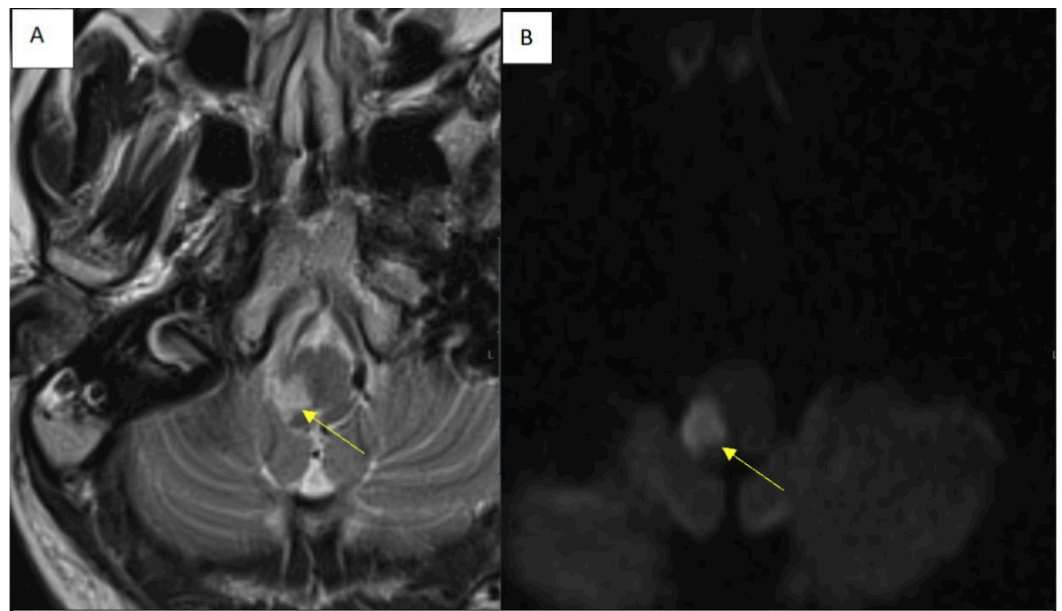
Magnetic resonance imaging (MRI) brain imaging axial T2 weighted imaging (T2WI) and diffusion weighted imaging (DWI) sequence at presentation. (A) Acute right lateral medullary infarct (yellow arrow) in the axial T2WI. (B) Acute right lateral medullary infarct (yellow arrow) in the corresponding DWI.
